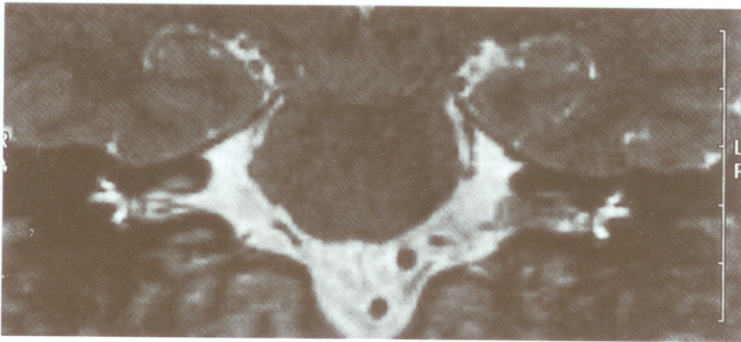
Coronal T2 weighted FSE MR image of a patient with a left sided acoustic neuroma (seen on the right side of the figure).
